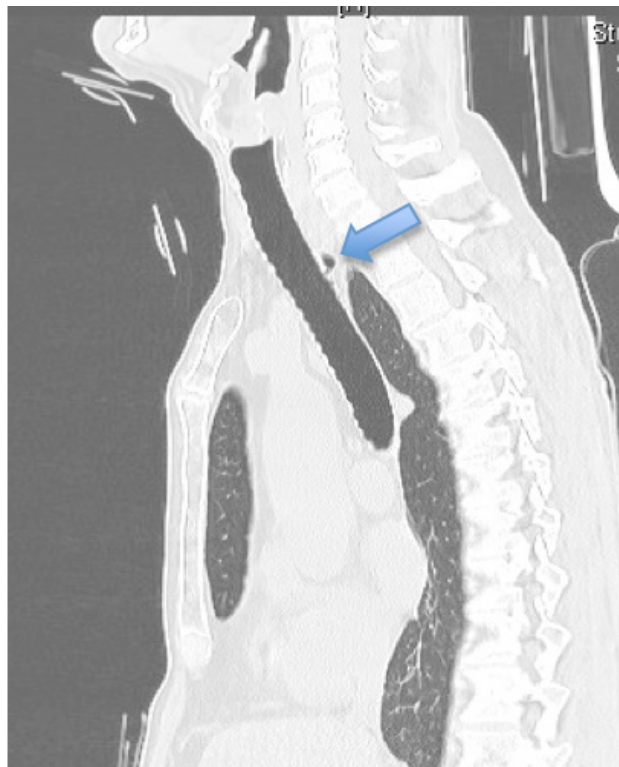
Tracheal Diverticulum: CT sagittal scan showing a paratracheal air collection (arrow).
